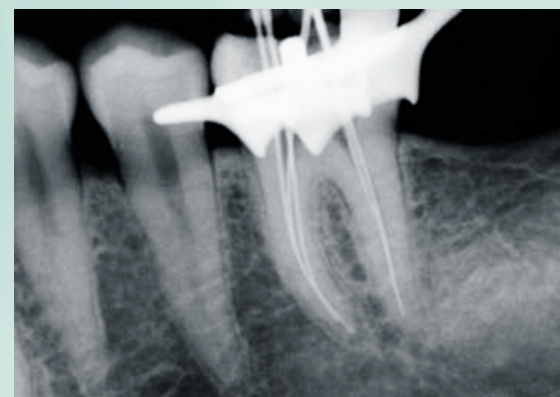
Radiograph with instruments placed at working lengths determined by an apex locator.
